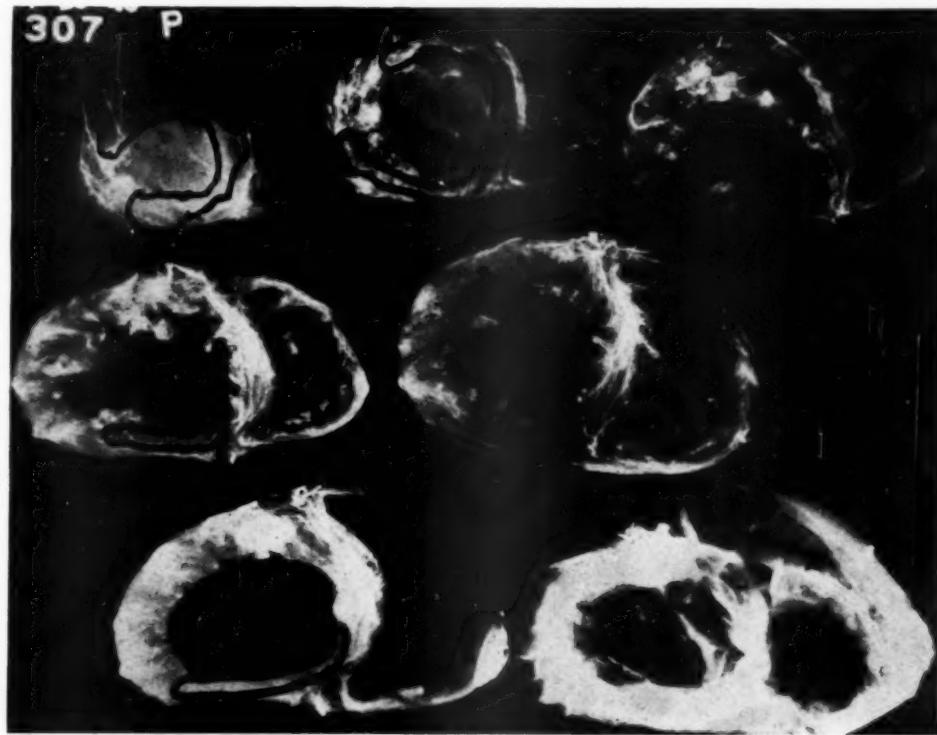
Roentgenogram of the injected heart in Case 67.
